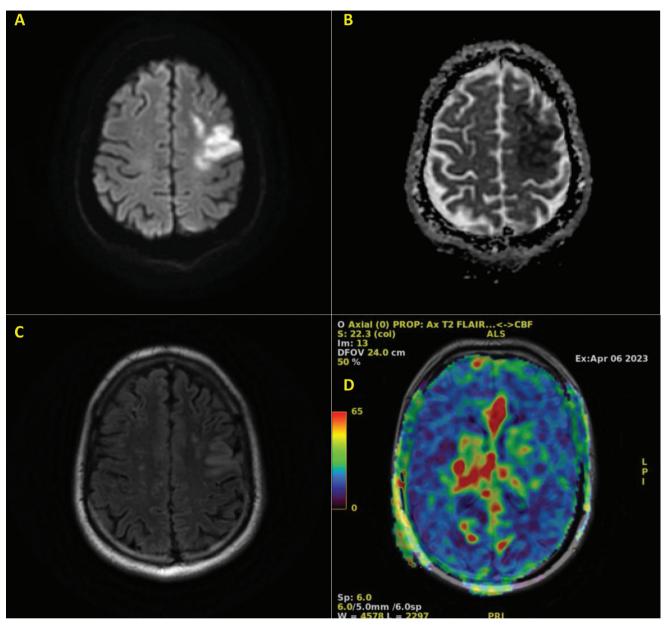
Axial head MRI showing (A) DWI sequence of hyperintensity on the left cortical-subcortical frontal region with (B) concurrent hypointensity on ADC, and (C) matched hyperintense T2-FLAIR sequence, indicating late hyperacute onset of ischemic stroke. (D) arterial spin labeling (ASL) sequence of the same patient demonstrated relative hyperperfusion on the central of circle of Willis as a sign of high collaterals density with apparent hypoperfusion of the left cortical area, suggesting poor cerebral perfusion on the cortical and subcortical area
